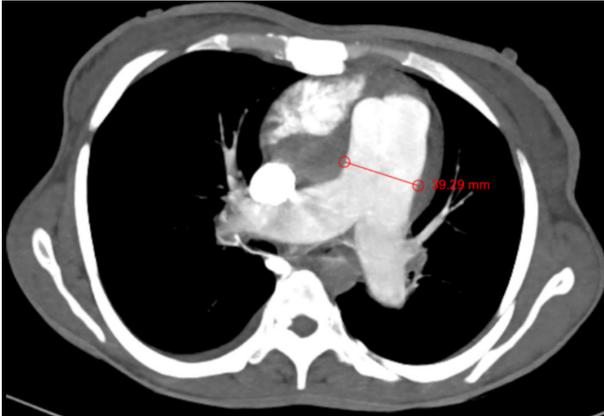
CT pulmonary angiography axial section of thorax at the level of bifurcation of pulmonary artery revealing dilated pulmonary artery measuring 39.29 mm in diameter.
